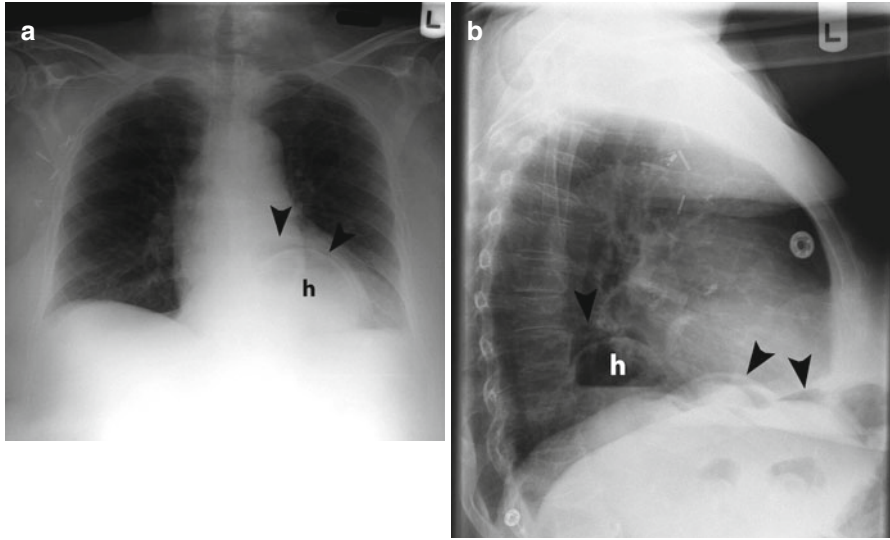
Free intraperitoneal air. AP (a) and lateral (b) chest radiographs show linear lucencies (arrowheads) under the diaphragm due to free intraperitoneal air. Note that some of the free air extends above a large hiatal hernia (h). Laparotomy revealed a gastric rupture
